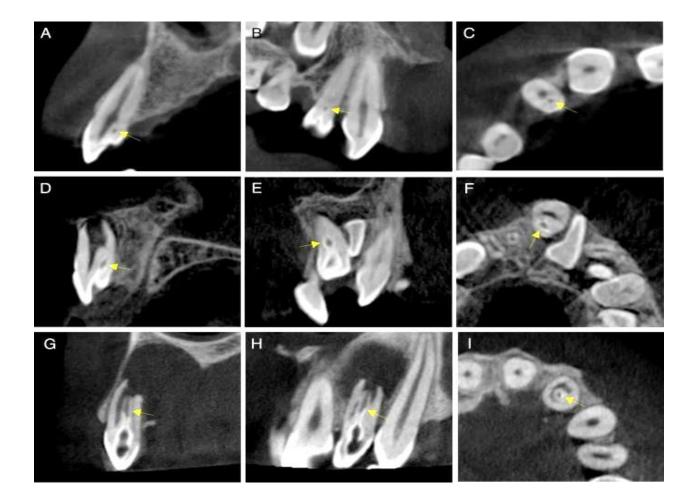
Assessment of dens invaginatus and its characteristics in maxillary anterior teeth using cone-beam computed tomography.
